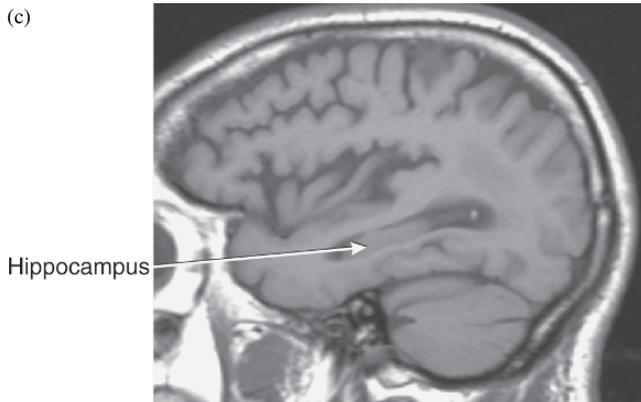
(a) Cross section of the hippocampal formation and parahippocampal gyrus. (b) The phylogenetic and ontogenetic development of the hippocampal formation as a result of the enfolding of the medial temporal cortex (adapted from P. Gloor, 1997). (c) through (e) The hippocampal formation in progressively deeper sagittal MRI images, and (f) on an axial cut at the level of the midbrain. Abbreviations: AI, alveus; CA1 → CA4, contiguous sections of the hippocampus proper; CS, collateral sulcus; DG, dentate gyrus; E-RC, entorhinal cortex; FDS, fimbriodentate sulcus; Fm, fimbria; HS, hippocampal sulcus; LV_{IH}, lateral ventricle, inferior horn; PreS, presubiculum; ParS, parasubiculum; Sub, subiculum; WMP, white matter pathway.
